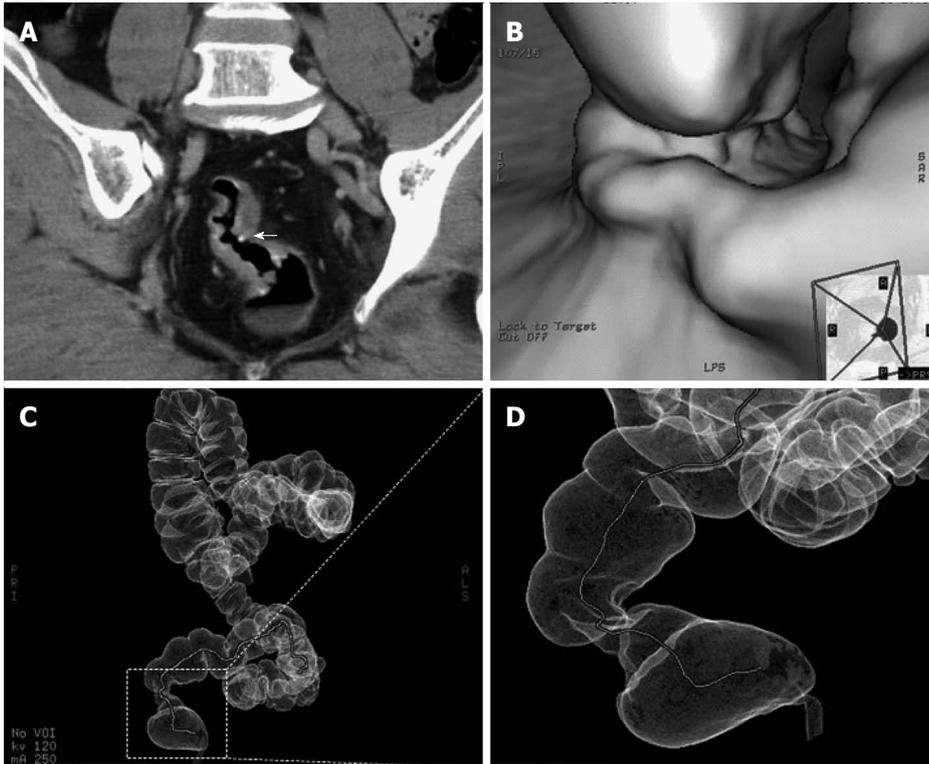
Computed tomography presentation. A: Computed tomography (CT) scan showing curvilinear calcification in the rectosigmoid colon and calcified, conglomerate nodules (arrow) protruding from the wall of the rectosigmoid colon; B: Lobulated polypus in the rectum; C, D: CTVC enables three-dimensional view of walls of the colon as a result of reconstruction of multislice CT images. The colorectal stenosis is showed in the area surrounding by dotted lines. CTVC: CT virtual colonoscopy.
